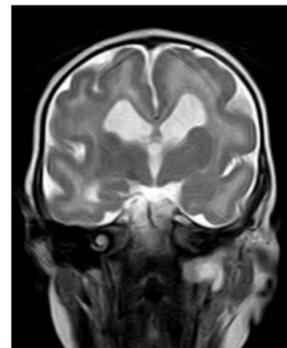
Brain MRI with ventriculomegaly and pachygyria
